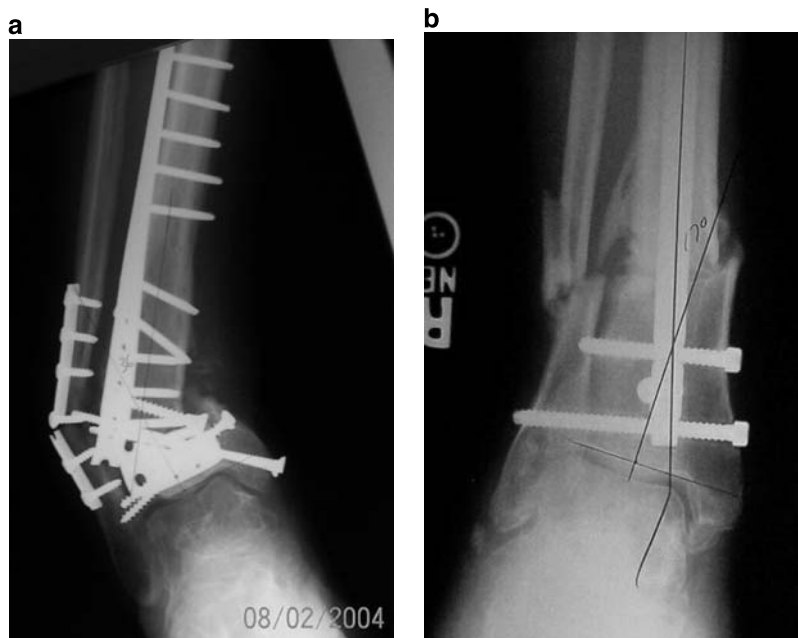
a AP x-ray of an atrophic mobile nonunion of the distal tibia/fibula with deformity and retained hardware. b AP x-ray showing a normotrophic partially mobile nonunion with retained IM nail and valgus deformity
